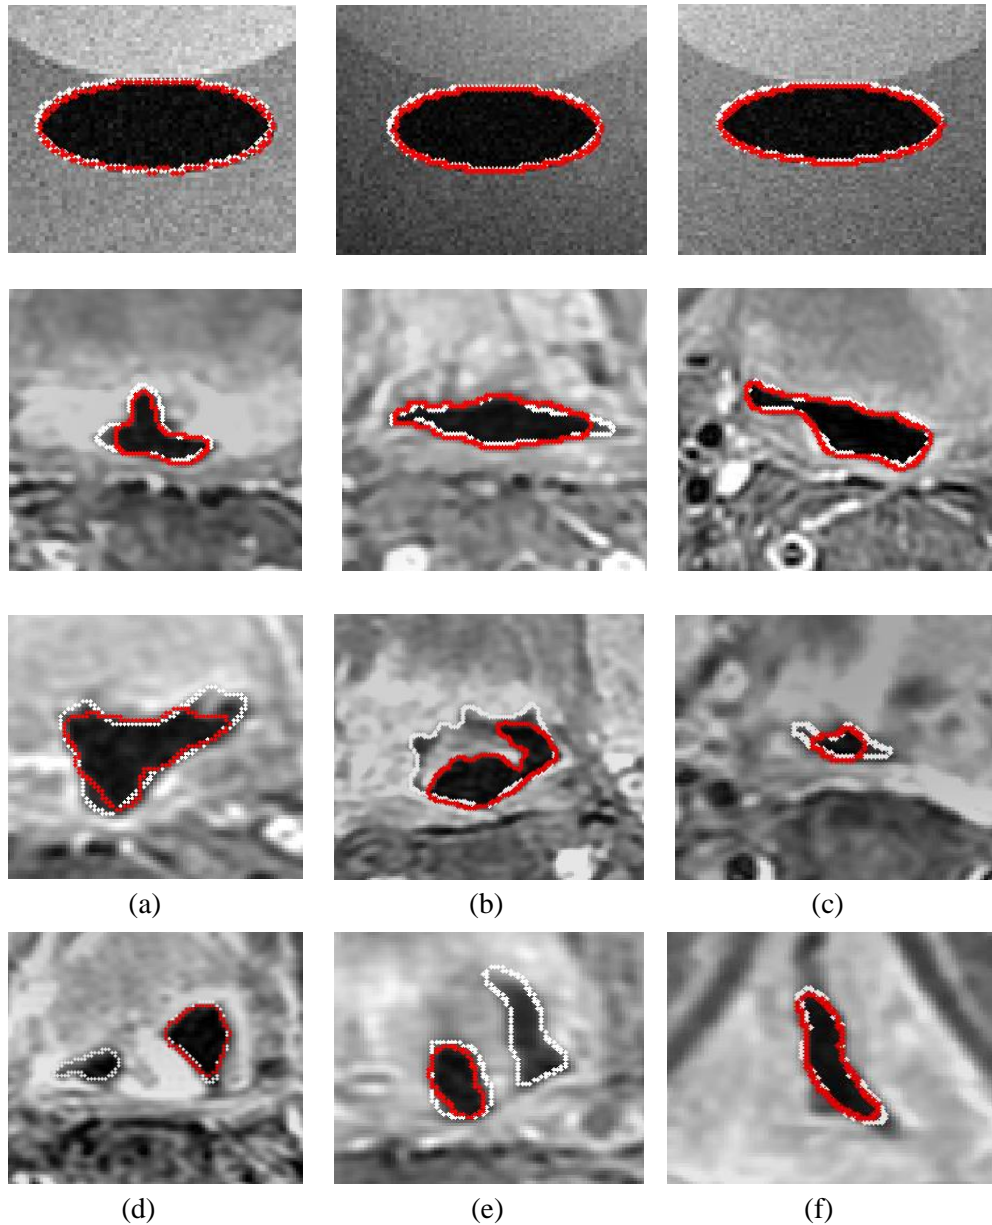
Qualitative results of automatic throat detection algorithm (ThDA) on MRI slices from different patients (red outline: ThDA, white outline: reference outline) (first row- synthetic data). ThDA algorithm can successfully detect the throat region of various shapes, sizes and intensities from MRI images obtained using different imaging protocols.
